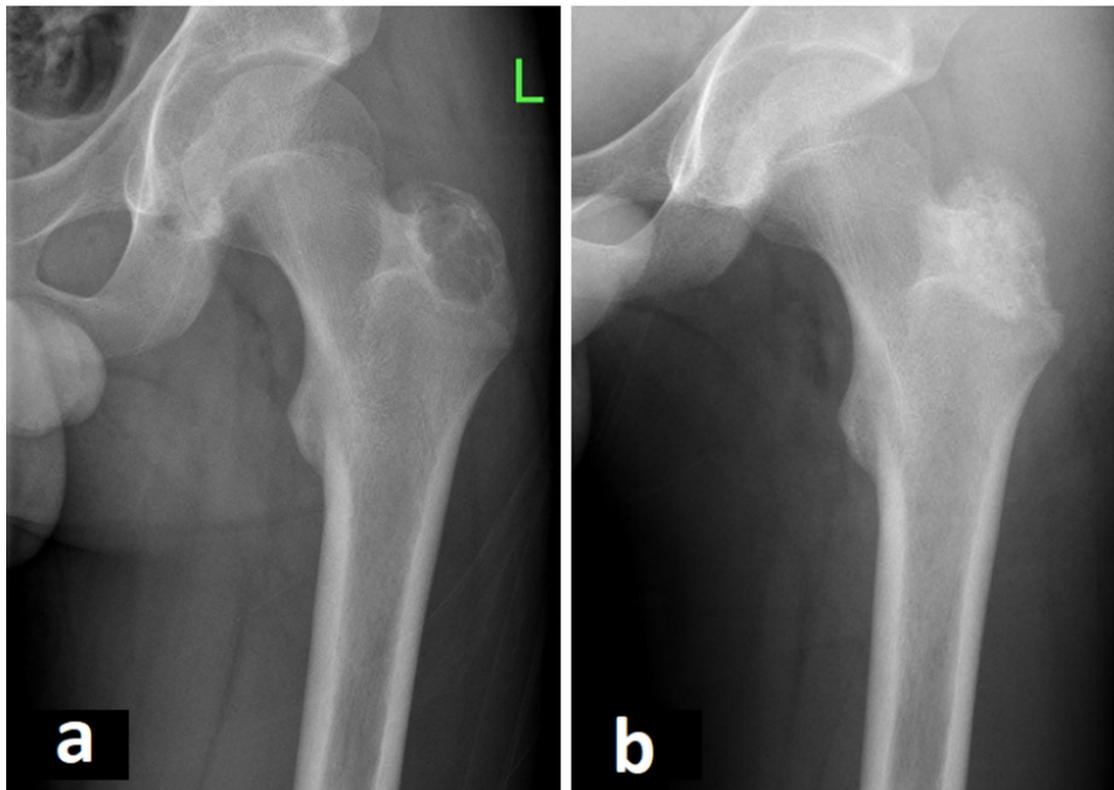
Curettage and bone grafting of a chondroblastoma of the left proximal femur (apophysis of the greater trochanter) in an 15-year-old boy (3a:preoperative radiography, 3b:postoperative radiography).
